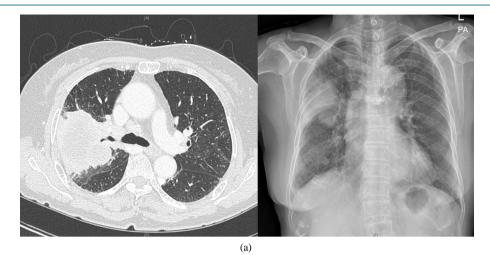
Chest X-ray of 55-year-old female patient with bilateral metastasis of lung cancer. (a) Chest X-ray in September 2013 showed bilateral multiple metastasis of lung cancer; (b) After 2 months of bilateral thoracic oncothermia with chemotherapy, follow-up chest X-ray showed marked regression of bilateral lung metastasis.
